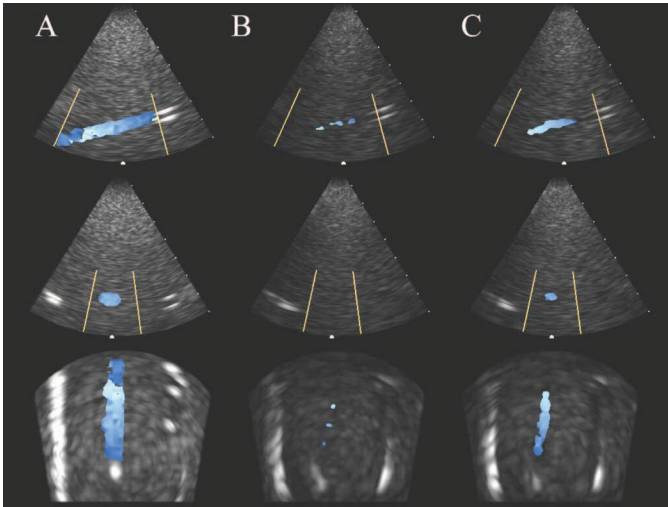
Physical aberrator Doppler correction. The columns show control (A), aberrated (B), and corrected (C) images of a 2-mm vessel with constant flow. The rows show the scanner's three orthogonal images. Images were taken with constant B-mode and color gain settings.
